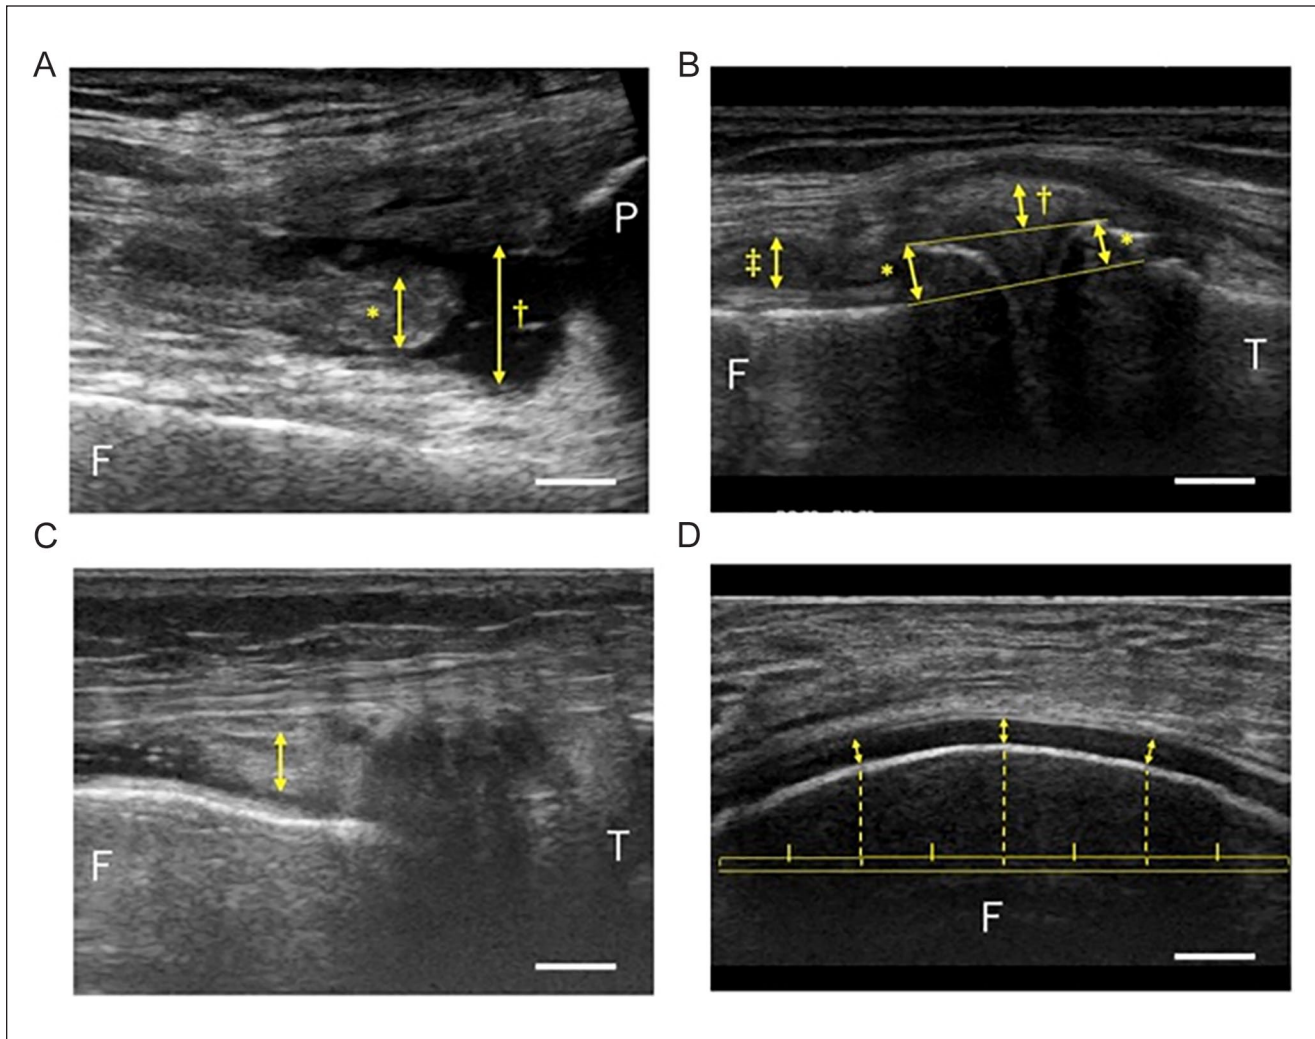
Representative ultrasonography images of each site. The yellow 2-way arrows indicate the measurement of distance for ultrasonographic parameters. (A) Image at the suprapatellar pouch. * and † indicate the length of SPE and SPSH, respectively. (B) Image at the medial recess. *, †, and ‡ indicate the length of MMP, osteophytes, and MRSH, respectively. (C) Image at the lateral recess. Yellow double-headed allow indicate the length of LRS (D) Image at the medial condylar cartilage. The dotted line equally divides a segment into four parts and indicates the measurement points. Scale bar represents 5 mm. P = patella; F = femur; T = tibia.
